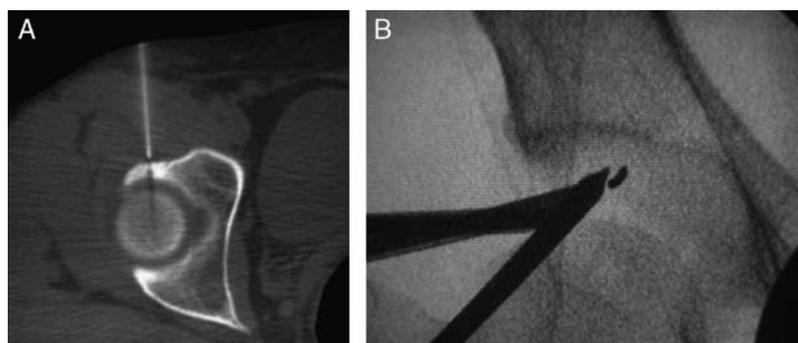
Patient 4. (A) CT-scan axial slice shows the Kirschner wire marking the region next to the lesion. (B) Fluoroscopy shows arthroscopic triangulation on the previously marked topography.
